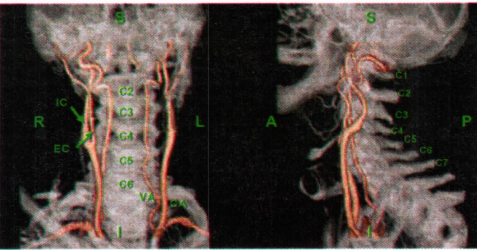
Anterior (Left) and lateral (Right) views of a Computed Tomography (CT) reconstruction of the neck with carotid (CA) and vertebral (VA) arteries highlighted. The internal (IC) and external (EC) branches of the carotid are visible. The vertebral artery passes through vertebral foramen and was not included in the characterization study. Cervical vertebrae are labeled. Due to limitations of the retrospective CT data, the carotid's position relative to C1 and C7 were not recorded in this study.
